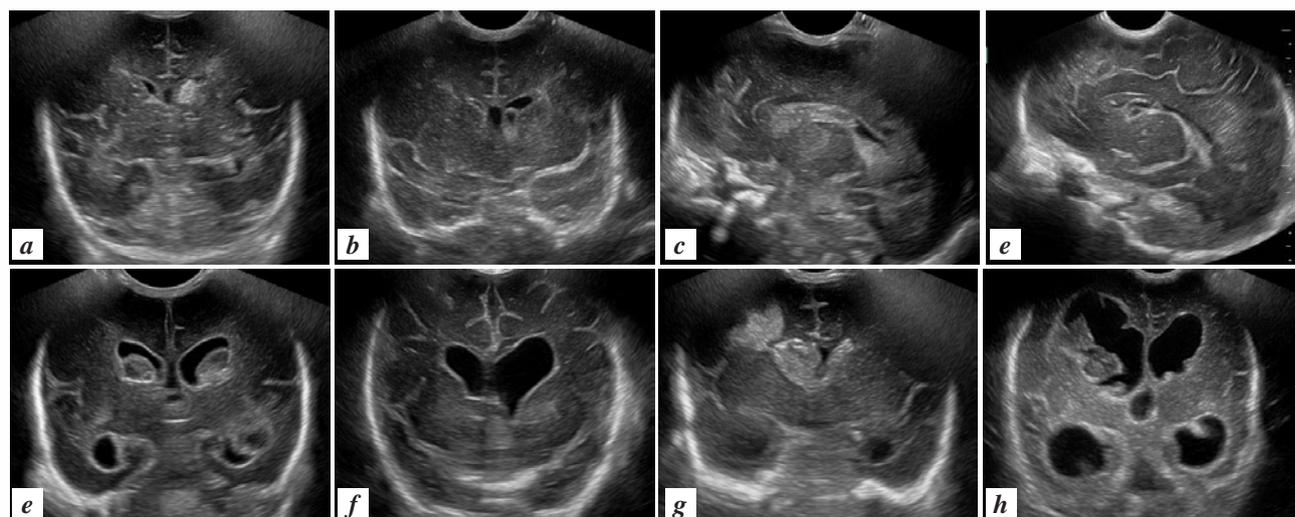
Neurosonographic changes and outcomes after intracranial haemorrhage.
